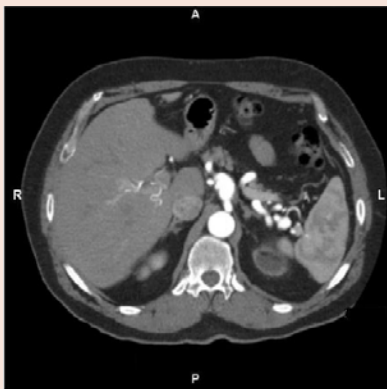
CT scan (axial view) of initial celiac artery aneurysm.
